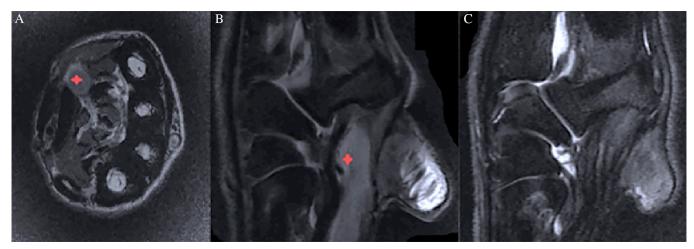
MRI images using proton density-weighted sequence after contrast administration. The tumour is labelled with a red asterisk in images A and B. Image A is in transverse plane sectioned at the level of the proximal metacarpals and images B and C are sagittal sections at the level of the carpus. Image C is from an MRI obtained 11 months following the initial surgery showing absence of a contrast-enhancing structure. In Image A, dorsal is to the right of the image and the top of the image corresponds to the lateral aspect of the antebrachium. In images B and C, dorsal is to the left of the image, palmar to the right, proximal to the top and distal to the bottom
